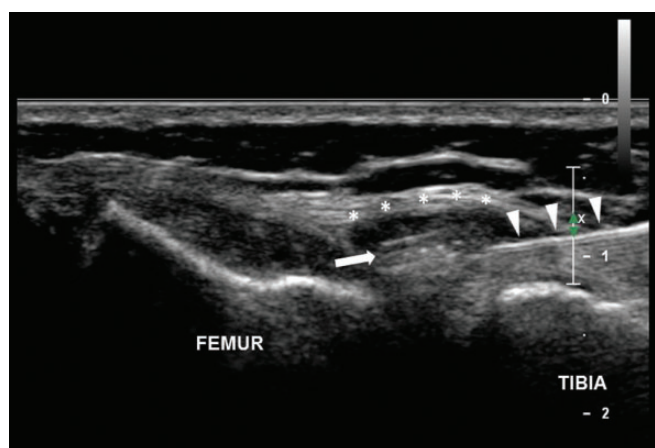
Case 2. Long-axis sonogram over the medial joint line. A 27-gauge (30-mm) needle (arrowheads) is used to infiltrate the bursa (asterisks) with 1% lidocaine for diagnostic purposes. The meniscal suture (arrow) is better visualized with surrounding hypoechoic injectate.
